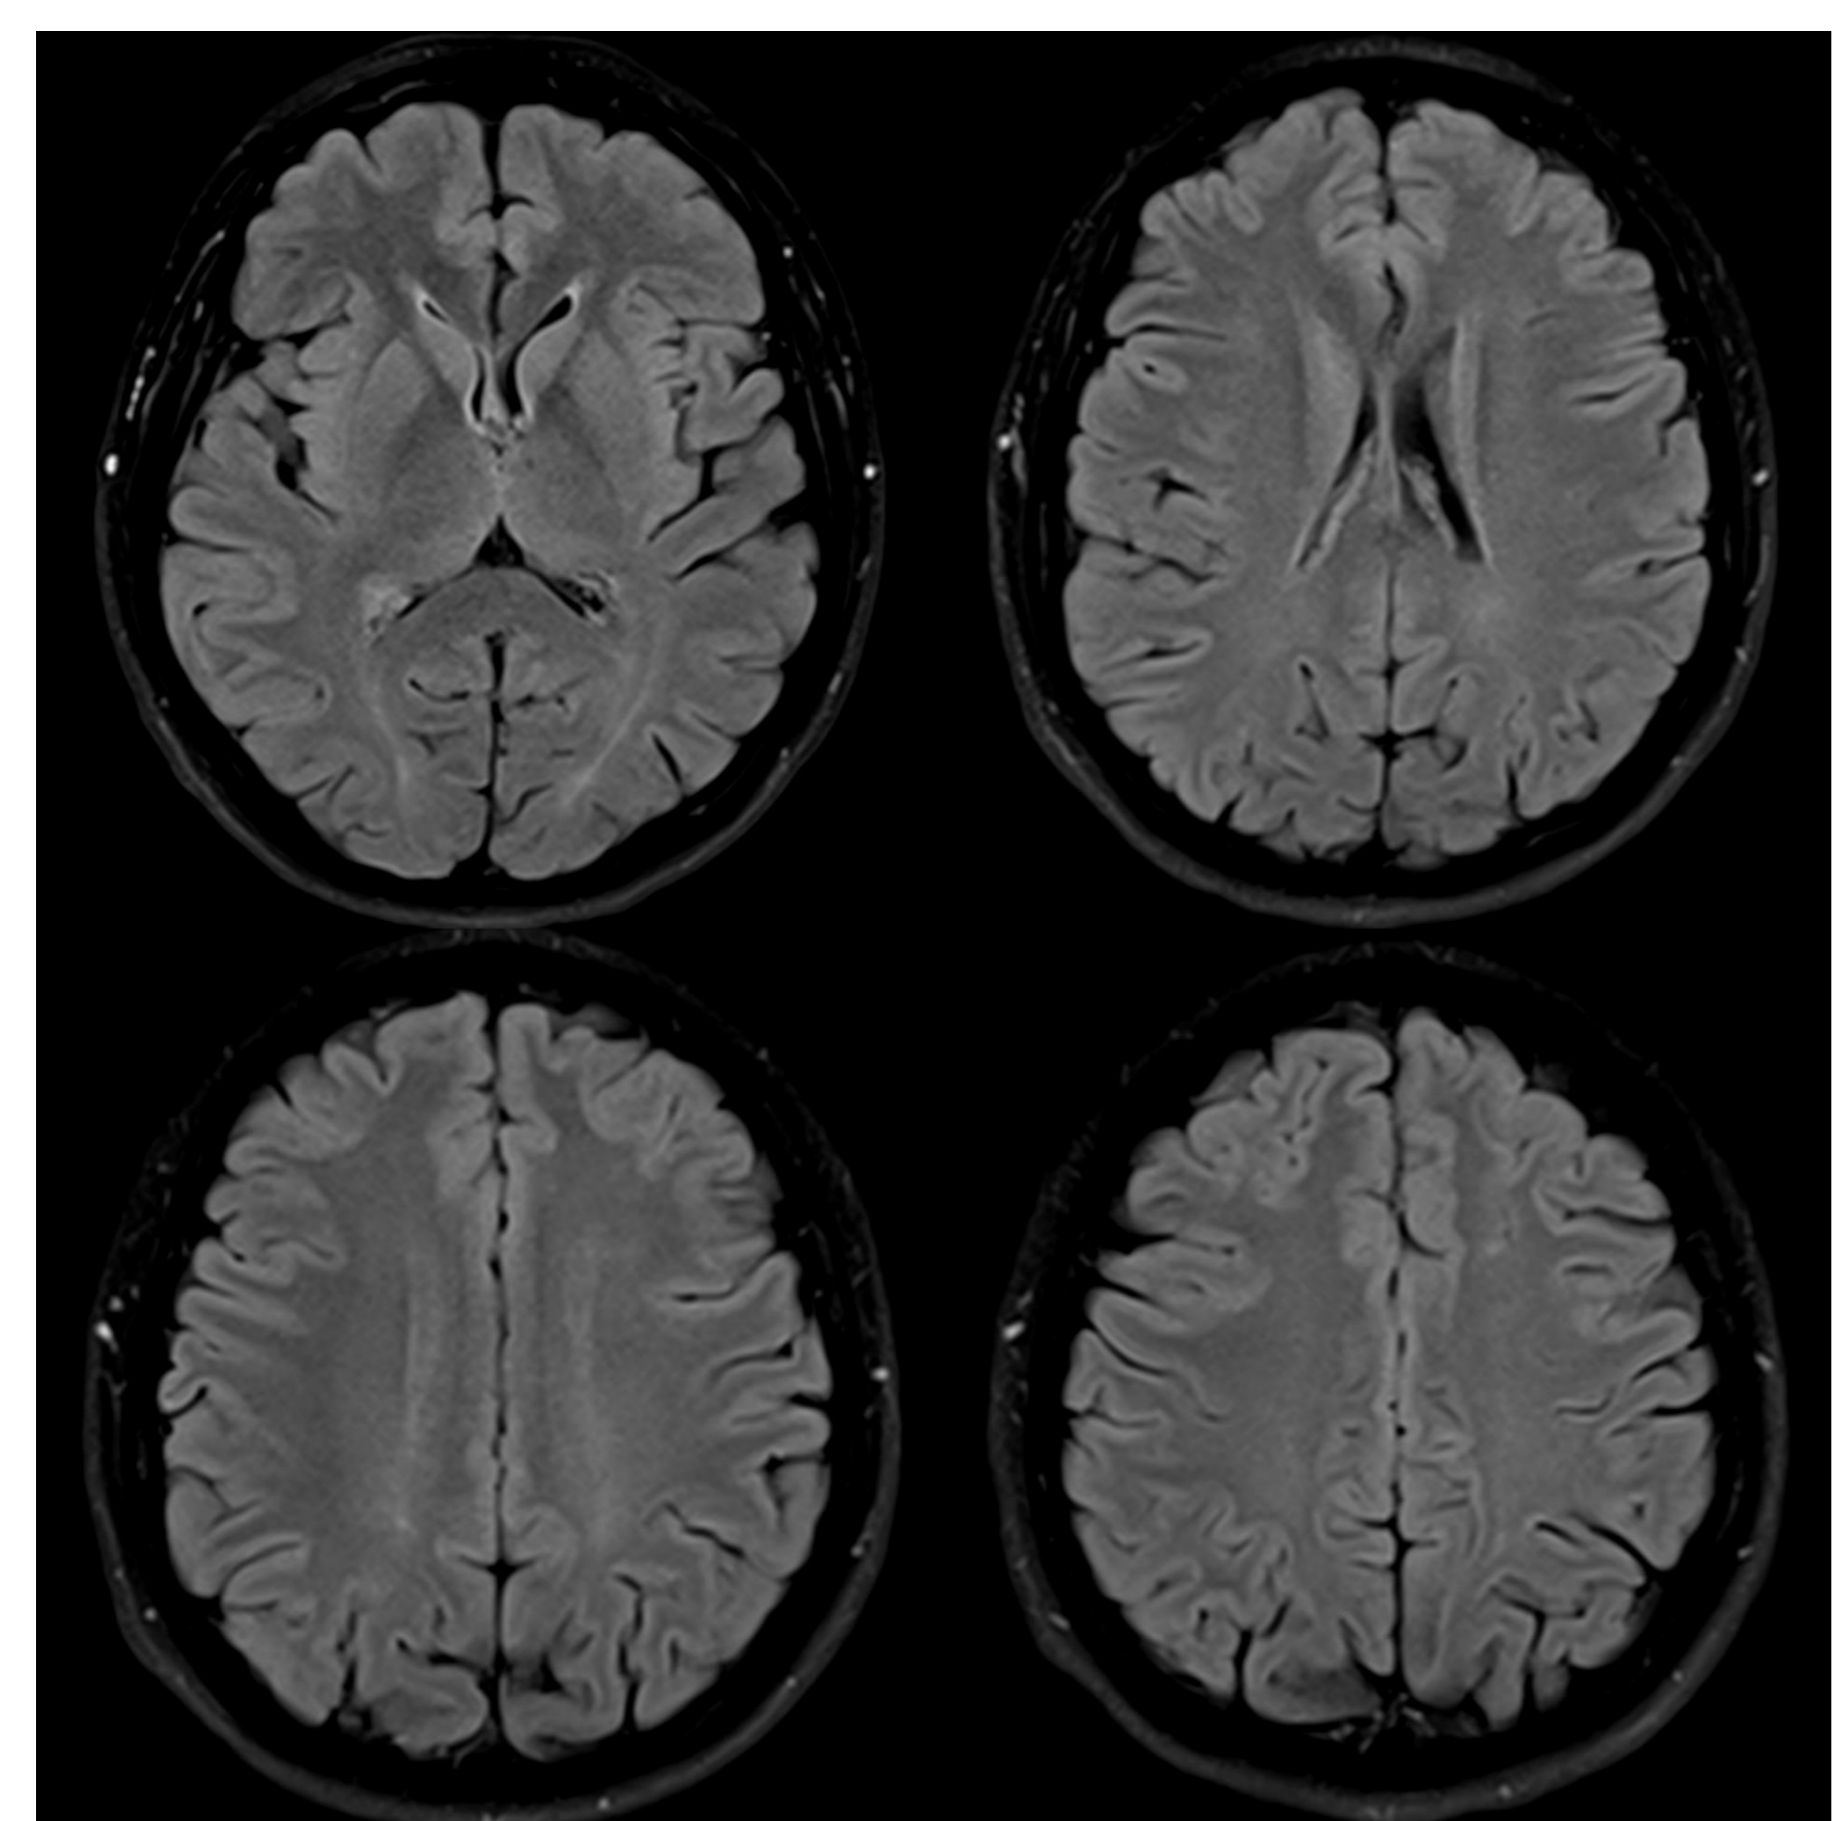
Results of preoperative brain MRI. The MRI showed punctate white matter hyperintensities on T2w-FLAIR images, particularly in regions corresponding to the carotid artery territory, indicating mild ischemic changes.
